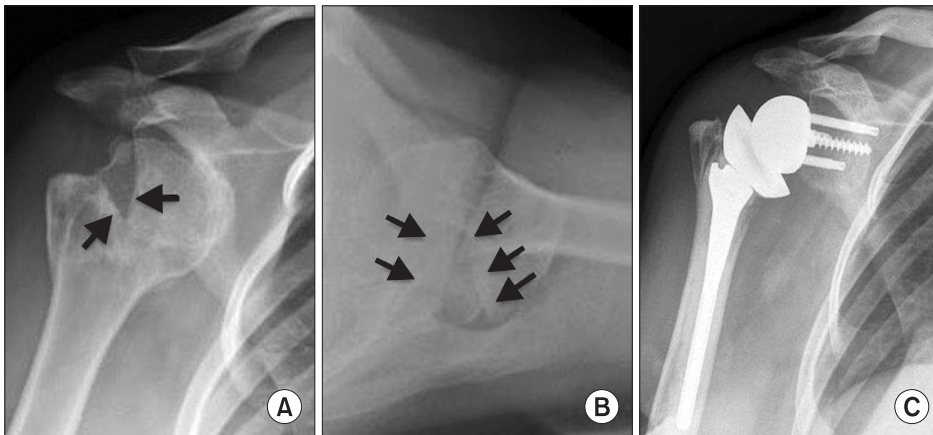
A 42-year-old female patient with chronic locked anterior dislocation. The anteroposterior (A) and axillary (B) preoperative conventional radiographs of the shoulder show a severe engaged Hill-Sachs lesion (multiple arrows) and unreduced chronic anterior dislocation. (C) Conventional anteroposterior radiograph of the shoulder at 8 months' follow-up shows a well-fixed prosthesis.
